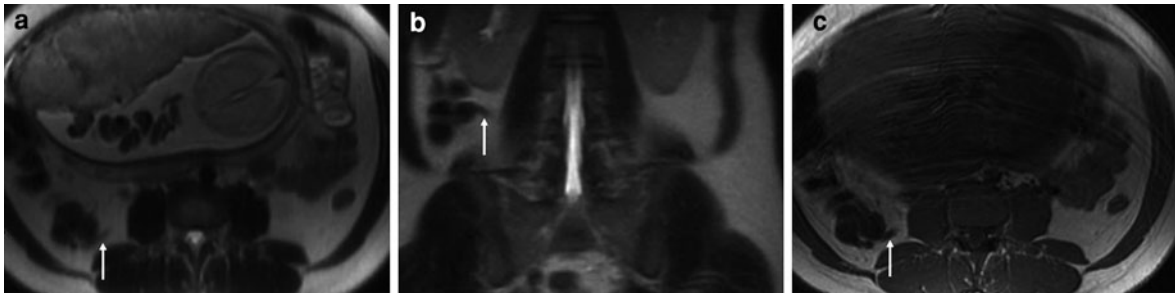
Normal appendix in a 28-year-old pregnant woman. Axial (a) and coronal (b) T2-weighted single-shot fast spin-echo image and T1-weighted gradient-echo image (c) show a
